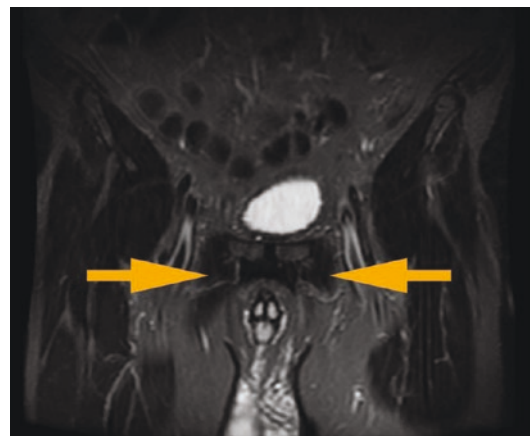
MRI imaging of severe bilateral adductor longus tendinosis
